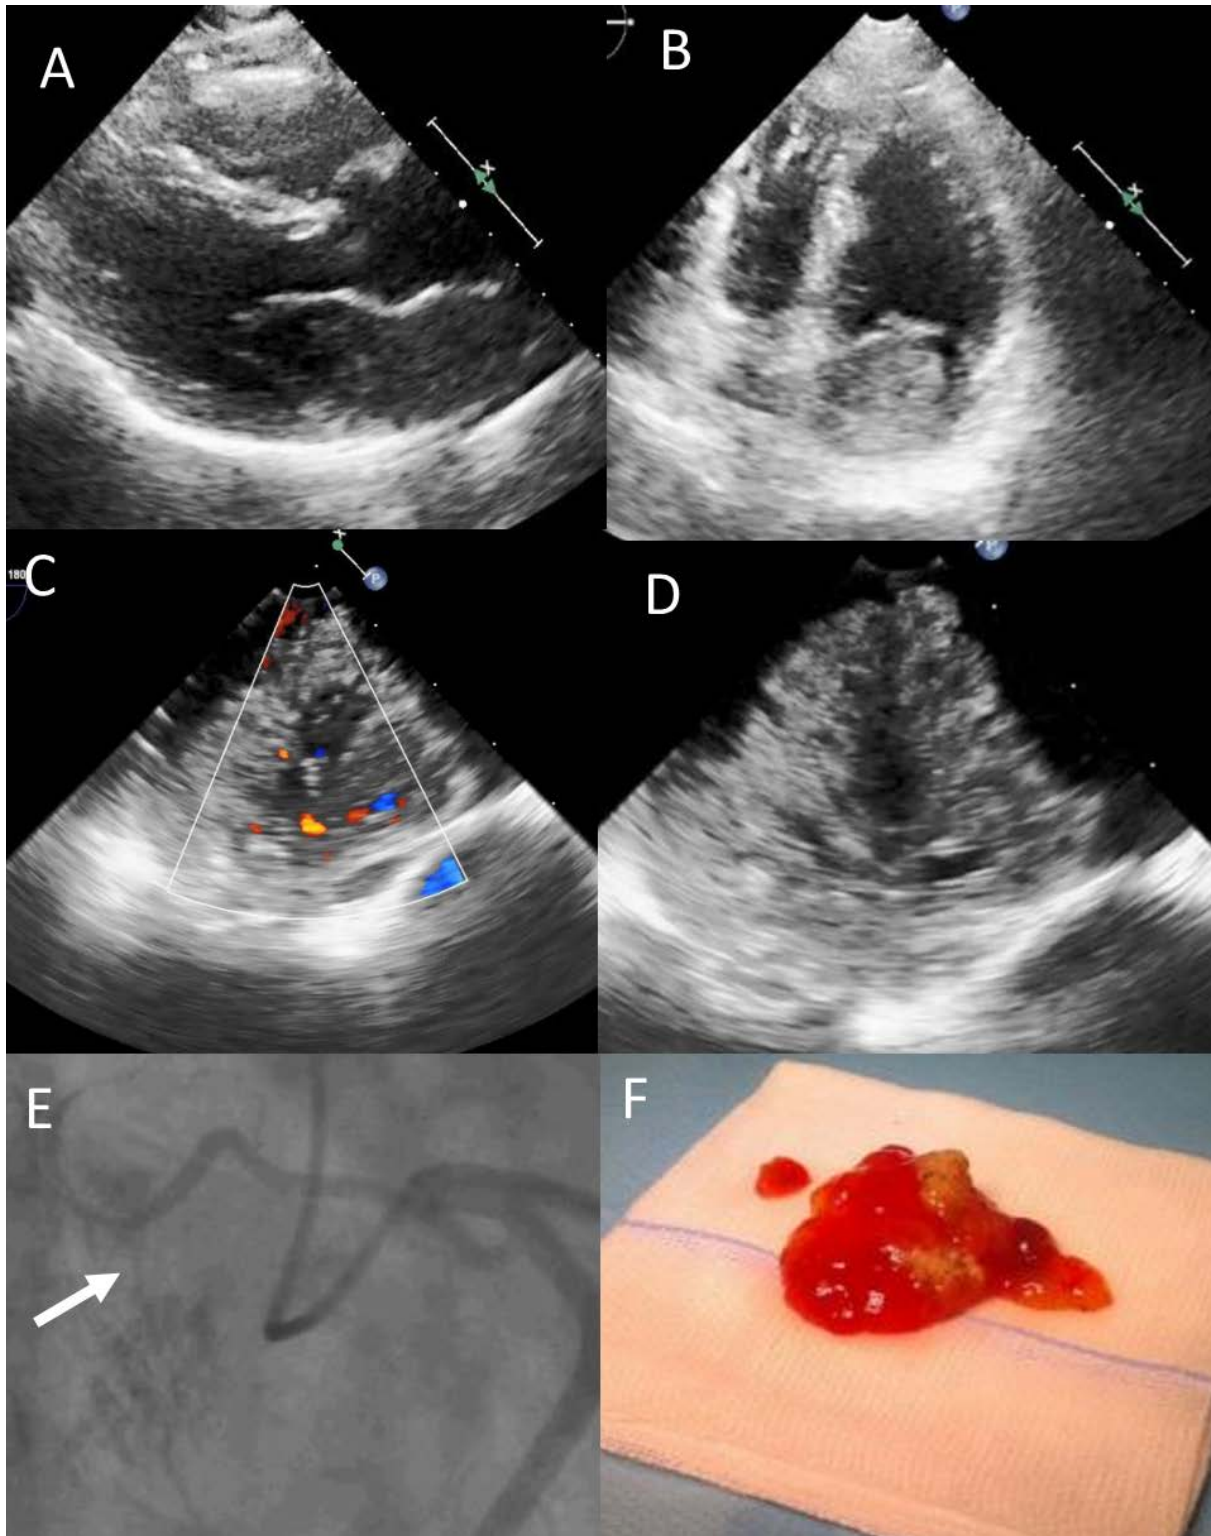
Cardiac myxoma, visualized using A. Transthoracic echocardiography — parasternal long axis view; B. Transthoracic echocardiography — four chamber view; C. and D. Transesophageal view. Branch of the right coronary artery vascularizing myxoma in the left
